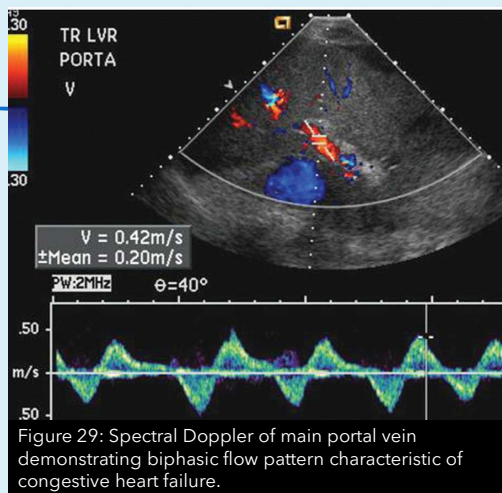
Spectral Doppler of main portal vein demonstrating biphasic flow pattern characteristic of congestive heart failure.
